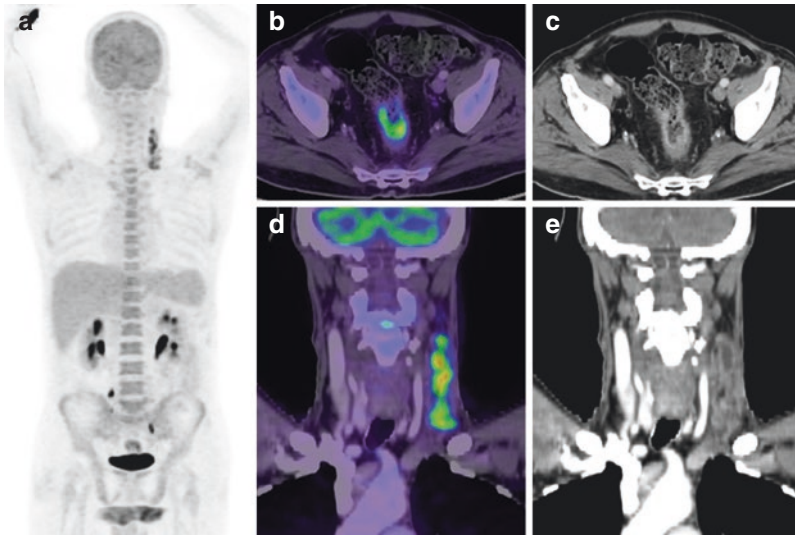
A 53-year-old man diagnosed with carcinoma of the rectum, 18F-FDG PET/CT (a - MIP) for initial staging revealed intense FDG uptake in the primary lesion in rectum (b, c). There was no evidence of any pelvic or abdominal lymphadenopathy. Intensely FDG-concentrating necrotic left cervical lymph nodes were noted (d, e). Biopsy of the cervical lymph nodes confirmed it to be due to tuberculous lymphadenopathy
